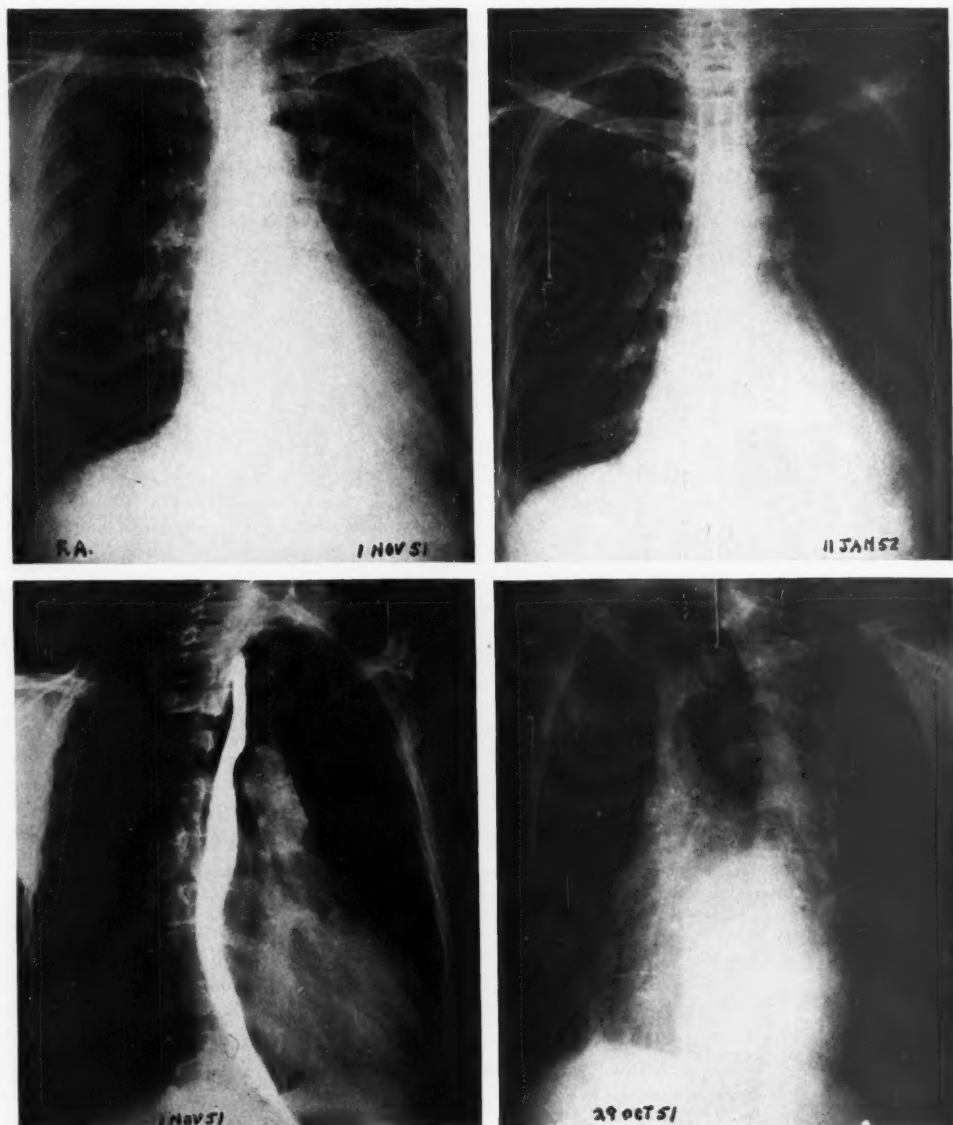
Patient F. A. Teleroentgenograms with right anterior oblique (lower left) and left anterior oblique (lower right) views made on dates indicated. In the x-ray of Jan. 11, 1952, a patch of consolidation can be seen near the right costophrenic sulcus.
